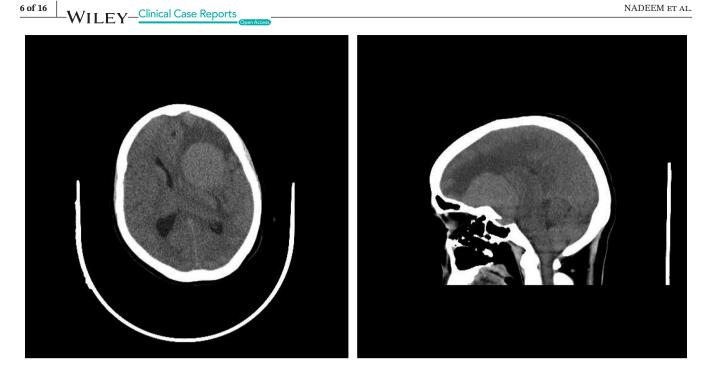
CT scan displaying a well-defined extra-axial homogenously hyperdense lesion at the left frontotemporal area, accompanied by surrounding edema. The lesion is causing mass effect, evident by the effacement of sulci along with compression of the ipsilateral lateral ventricle and a midline shift of approximately 0.8 cm to the right side.
